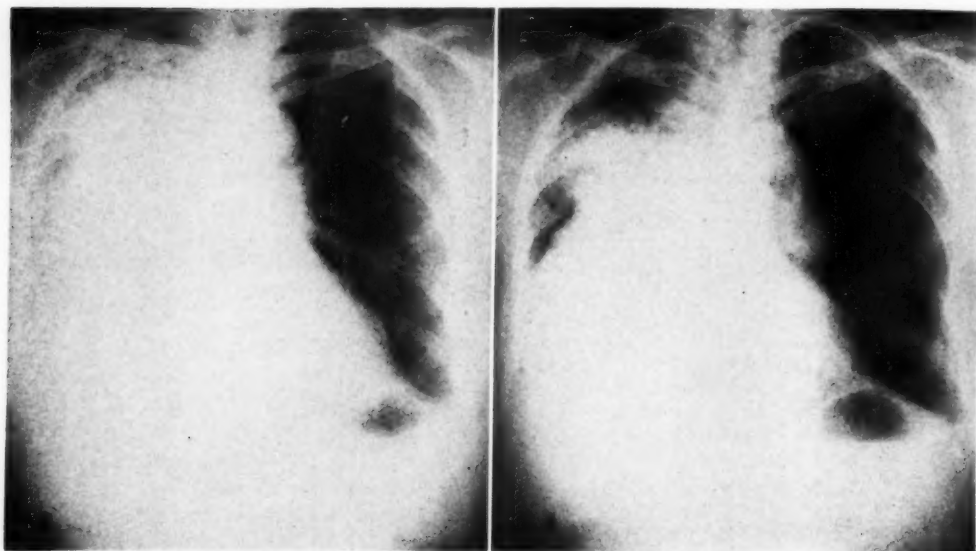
Chest film of Aug. 28, 1950, forty-eight days after completion of x-ray therapy, showing abnormal density over the entire right hemithorax. On this film the most marked changes are located in the central, heavily irradiated portion as opposed to the early changes seen in Fig. 2. There is a shift of the mediastinum to the right, indicating a decrease in lung volume. The patient was extremely ill. Following this x-ray study, treatment with ACTH was instituted.
